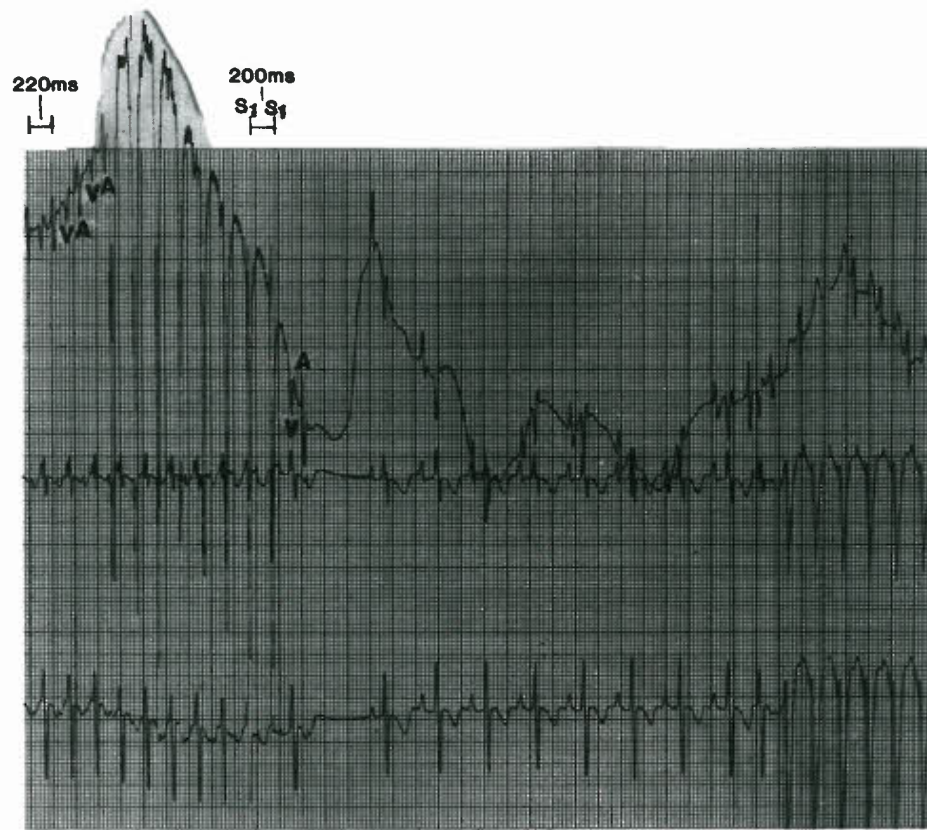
Unipolar transesophageal simultaneous recordings (top) with surface leads V2 and V3 from a 3-year-old boy with incessant normal and wide QRS SVT (220-ms cycle length) showing simultaneous transesophageal pacing (interelectrode distance 24 mm) and recording (interelectrode distance 2 mm). Using a quadripolar electrode catheter, the esophageal recording (V, ventricular; A, atrial) during tachycardia was interrupted by 8 beats of atrial pacing (200-ms cycle length), which converted the tachycardia to several beats of sinus before wide QRS reciprocating AV reentrant SVT recurred. Note the wandering baseline of the unipolar esophageal recording before, during, and after pacing.
